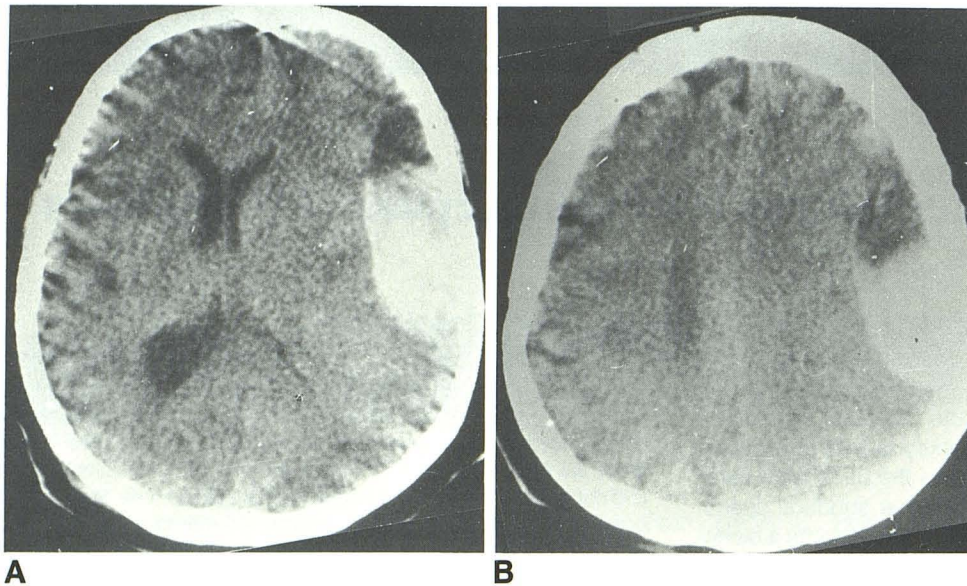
Case 2. Nonenhanced CT scans. A and B, Left large biconvex acute subdural hematomas. Margin of hematoma is almost perpendicular to skull wall. Note hypodense region in superior part of hematoma with fluid level.
